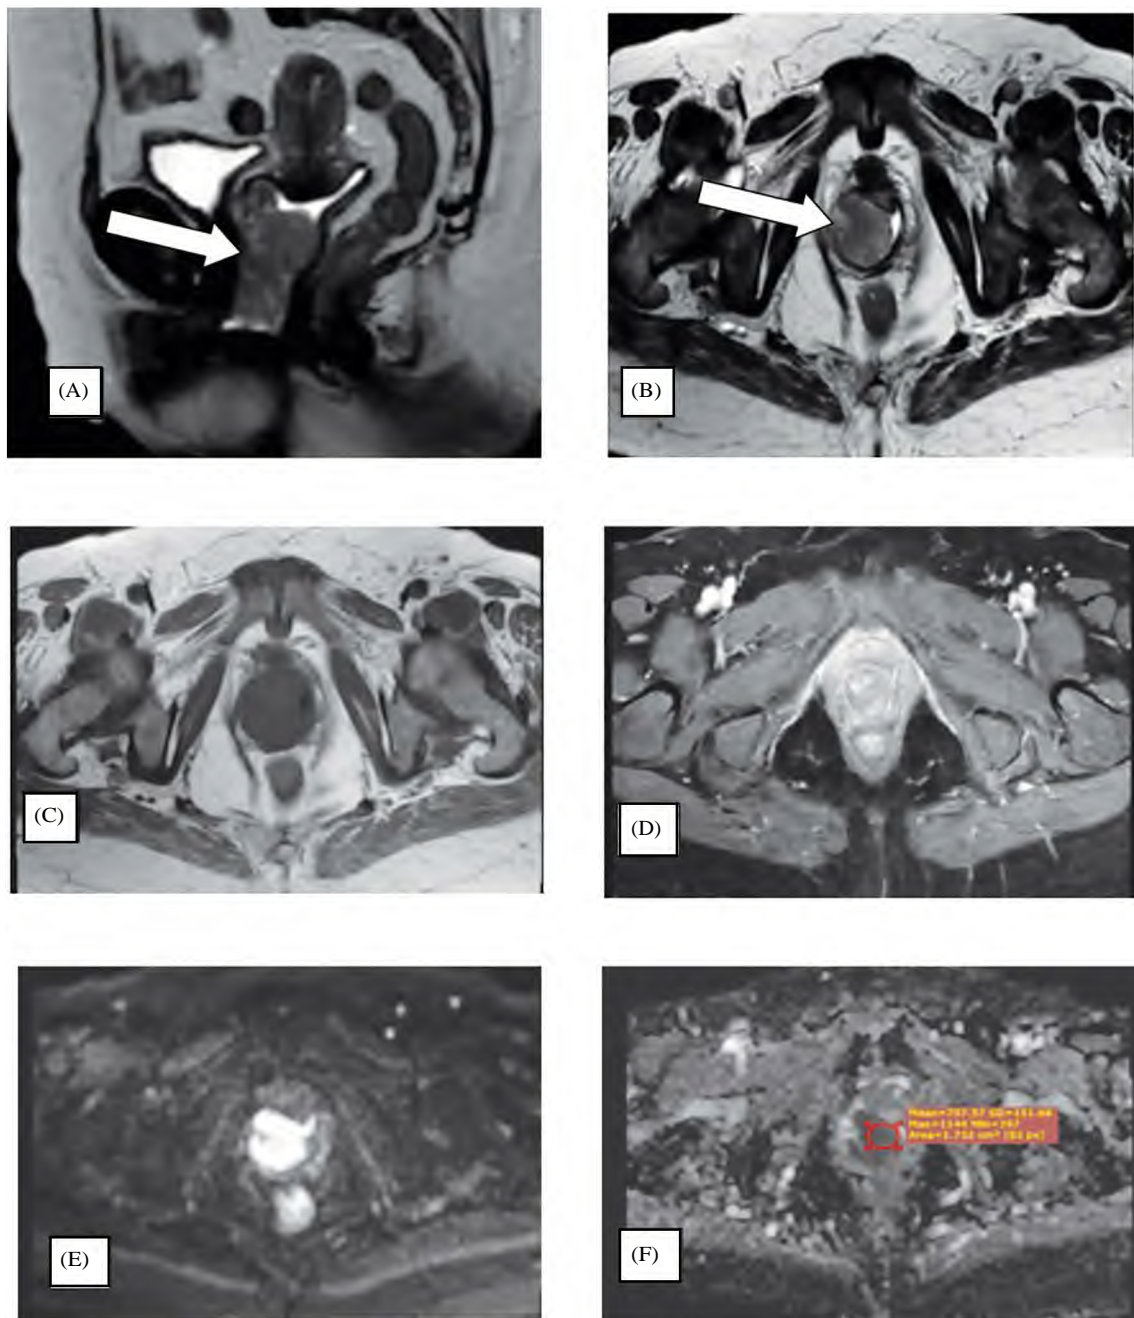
A 79-year-old female presenting with vaginal bleeding and pain. Sagittal T2WI (A) Axial T2WI (B) and axial T1WI. (C) Images reveal the vagina is distended with soft tissue lesion extending to the anterior fornix eliciting iso-intense signal in T1WIs and high heterogeneous signal in T2WIs. Yet there is a free bladder wall. Post-contrast. (D) It shows homogenous avid enhancement. DWI and ADC image. (E,F) The lesion shows a high signal on DWI and a low signal on the corresponding ADC maps. ADC value was $(0.707 \times 10^{-3} \text{ mm}^2/\text{s})$. The pathology was melanoma of the vagina.
